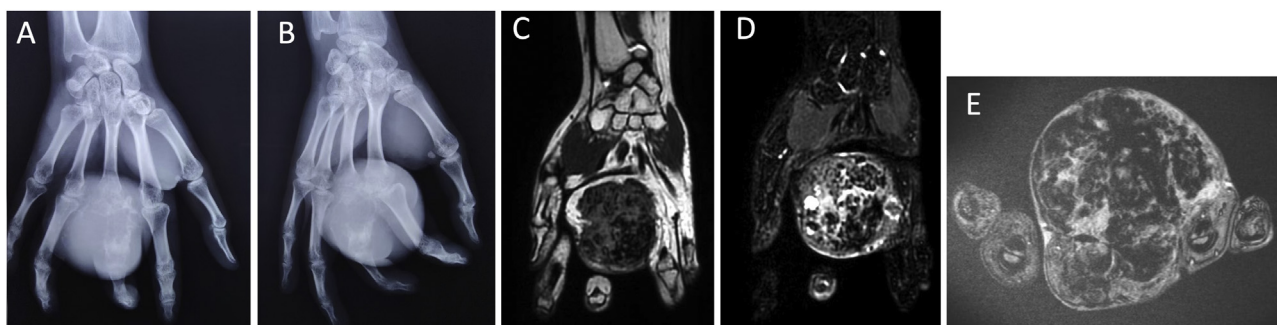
Hand radiographs from (A) posteroanterior and (B) oblique revealed an expansile lytic lesion involving the proximal phalanx of the third digit with cortical breach and gross soft tissue extension as well as extension into metacarpophalangeal joint. MRI images show a heterogenous mass appearing hypointense on coronal T1-weighted image (C), hyperintense on coronal (D) and axial (E) T2-weighted images.
